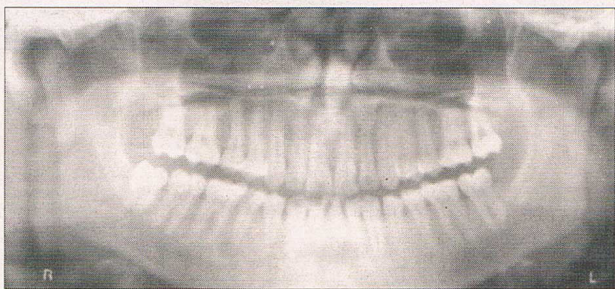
Panoramic radiograph revealing the absence of mandibular right and left central incisors and presence of a conical supernumerary tooth
